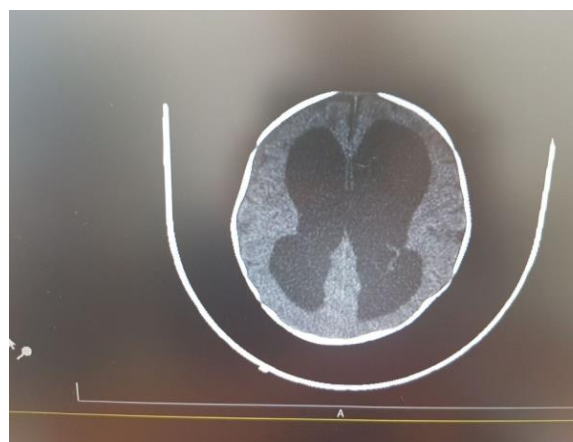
Brain computed tomography (CT) scan
